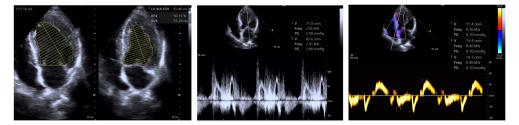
b.24. Evaluation of the LV function in case presented. Left: normal systolic function (2D, apical 4-chambers view); middle and right: mild type 1 diastolic dysfunction (E = 71 cm/s; A = 83 cm/s,  $E/e^2 = 7.35$ ) (4-chambers view, PW Doppler and tissue Doppler)
